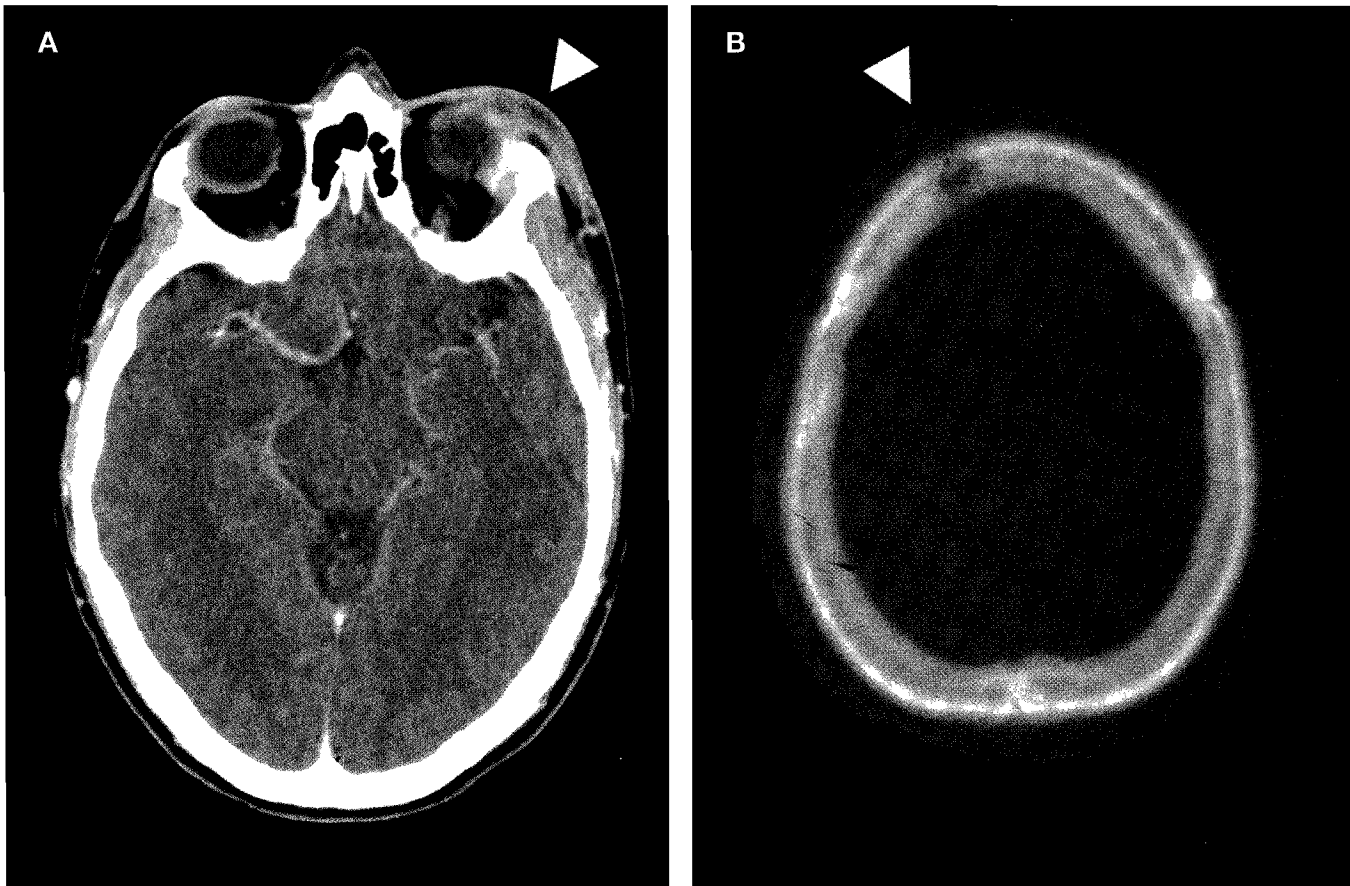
Figure – These CT scans demonstrate unilateral lacrimal gland inflammation, or dacryoadenitis (A, arrowhead), and destructive cranial osteitis (B, arrowhead) in a patient with early syphilis and HIV coinfection.
